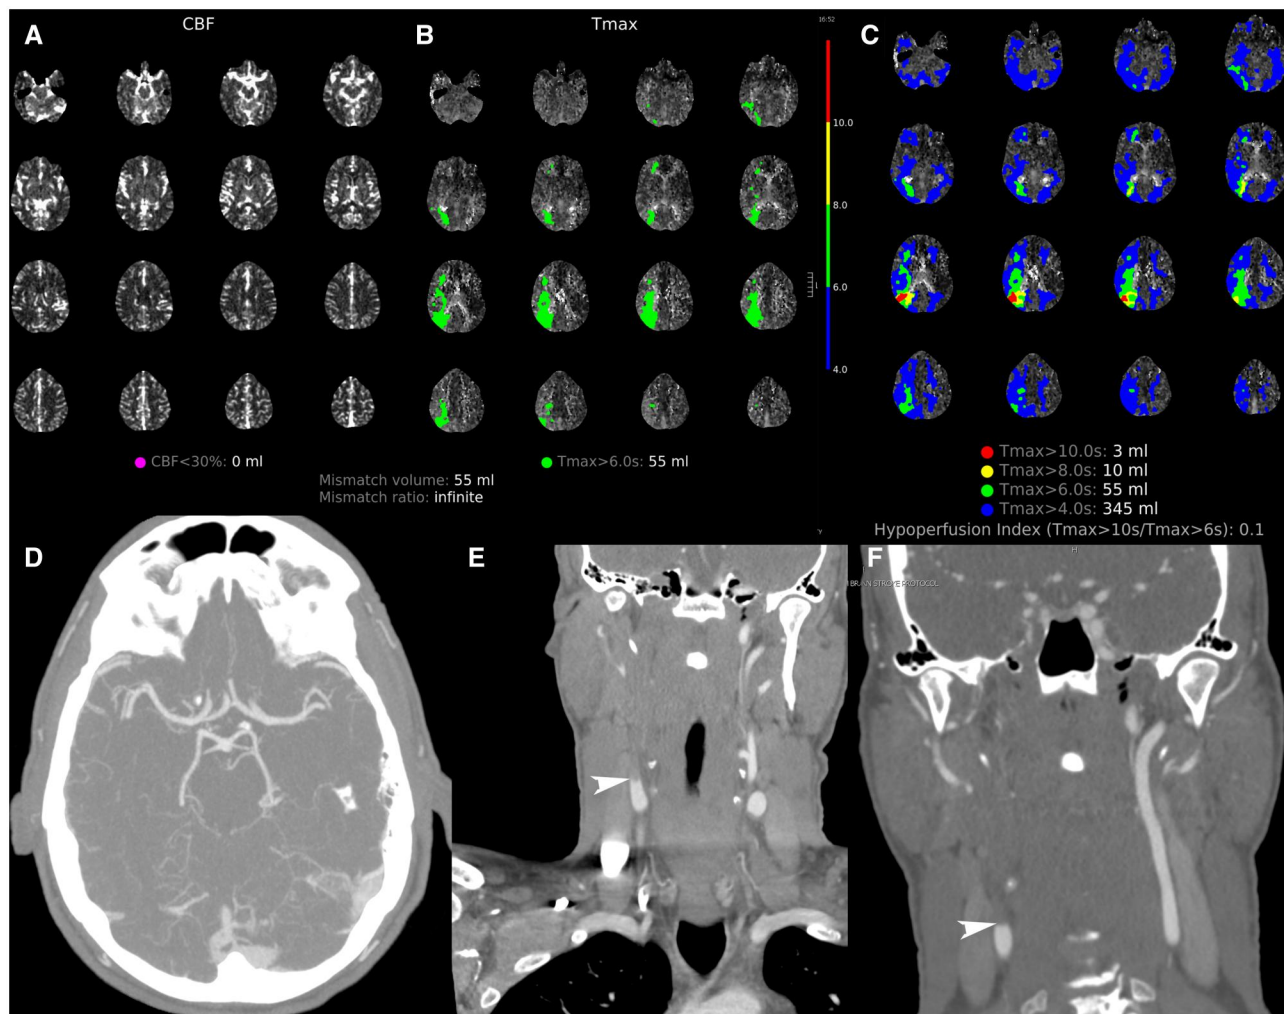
Output of CTP processing demonstrating (A) CBF and (B) Tmax > 6 s. (C) demonstrates TMax findings with different thresholds. (D) Axial MIPs of CTA images demonstrate no intracranial LVO. (E) and (F) show occlusion (arrowhead) of the cervical right internal carotid artery with widely patent left.
